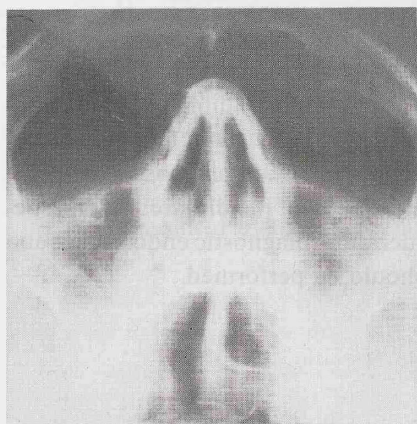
Waters' projection radiograph was interpreted as showing slight thickening of the antral mucosa.
